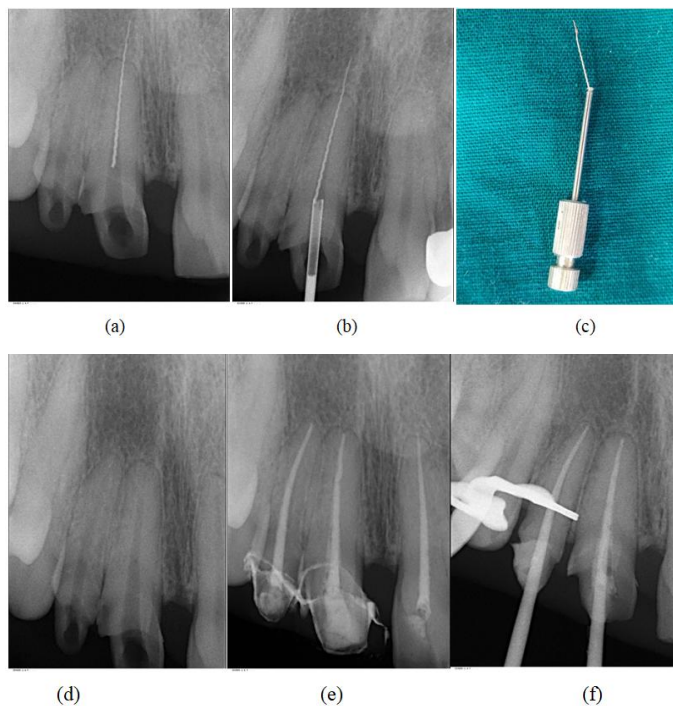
(a) – Pre Operative radiograph of separated fragment; (b) - Trephan centered over the fragment; (c) - separated instrument fragment; (d) -Post instrument retrieval; (e) – Master cone; (f) – Obturation
